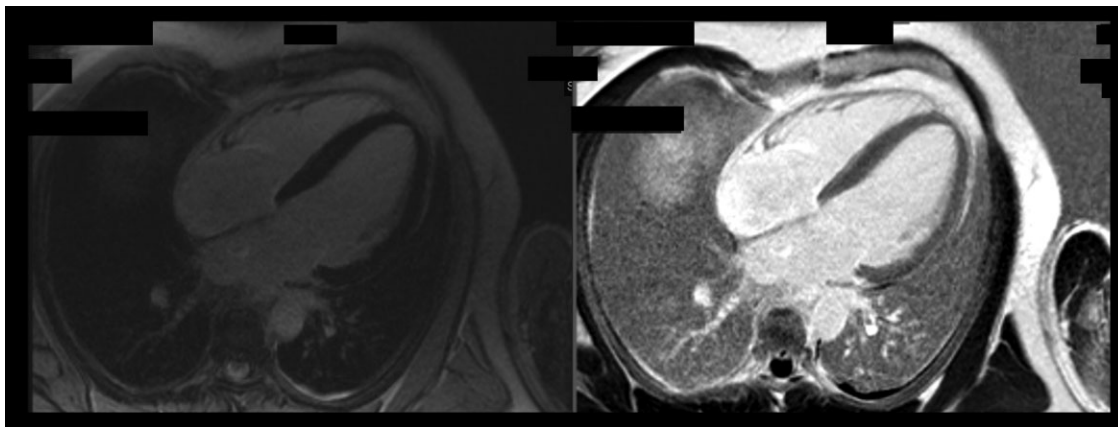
Sample of four-chamber images from cardiac magnetic resonance imaging, including phase-sensitive inversion recovery sequences, demonstrate a moderately dilated left ventricle with no evidence of inflammation or late gadolinium enhancement.
